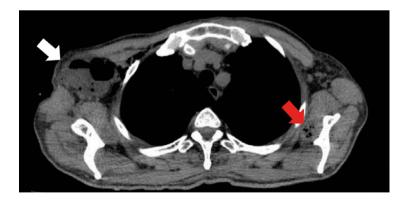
Contrast-enhanced chest CT scan.
